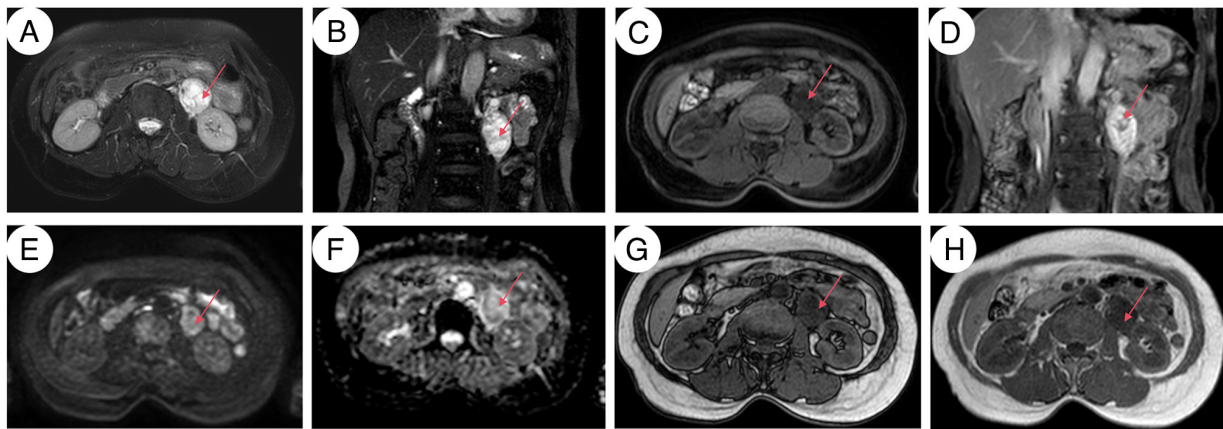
MRI of the retroperitoneal mass. (A) MRI T2 transverse. (B) MRI coronal images show the signal characteristics of the mass (red arrow) and adjacent structures. (C) MRI T1 transverse image. (D) MRI enhanced coronal image shows significant non-uniform enhancement. (E) Diffusion-weighted imaging demonstrated a mild high signal. (F) Apparent Diffusion Coefficient: Mild low signal, indicating mild diffusion restriction. (G) Out-of-phase: No signal drop vs. in-phase. (H) In-phase: Anatomical reference indicates no fat component.
